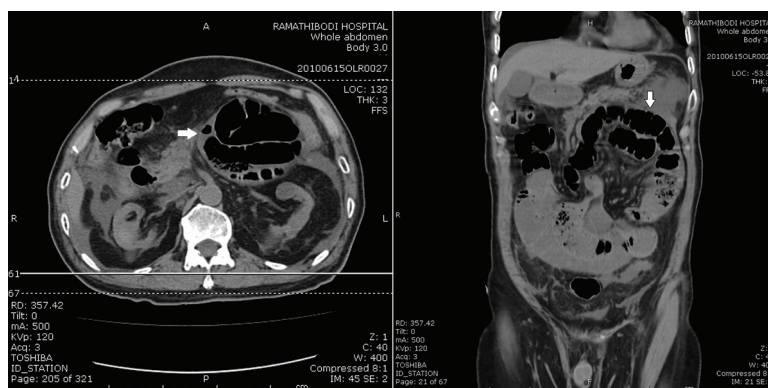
CT scan abdomen revealed sac-like mass (arrow) of the dilated small bowel loops located inferior to pancreatic body and tail in the left upper quadrant of abdomen.
